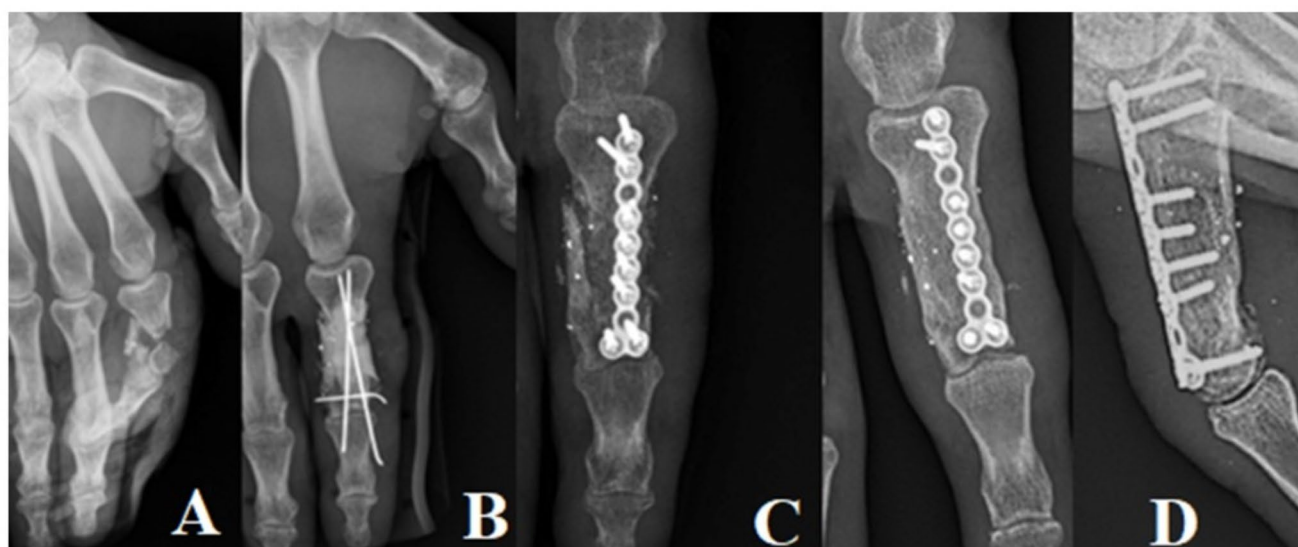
Radiographs showed a complex fracture of the first phalanx with bone loss (A). First step of induced membrane technique with pins stabilization (B). Second step of the membrane induced technique with bone graft and plate/screws fixation (C). Outcome with bone healing (D)
